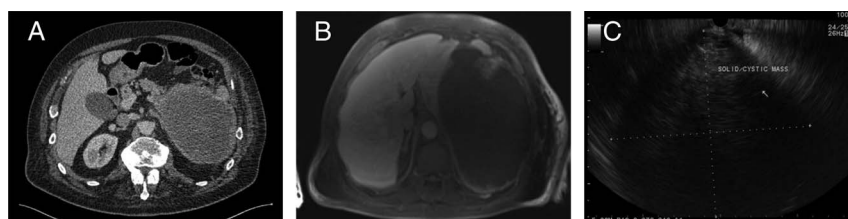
A 76-year-old man presented after a fall and a trauma series. Computed tomography scan (A) demonstrated a large, complex cystic mass between the pancreatic tail and the spleen. Initially felt to be a hemorrhagic lesion following the recent trauma, the complexity of the lesion prompted MRI evaluation. The MRI (B) demonstrated the lesion to arise from an expanded pancreatic tail. The fluid contents of the lesion appeared of intermediate high signal on T1 suggestive of hemorrhagic or proteinaceous characteristic and with more solid components within the peripheries of the lesion. Percutaneous ultrasound-guided drainage of the lesion yielded serous fluid for analysis, although cytological results did not demonstrate any malignancy. The patient underwent an EUS (C), which demonstrated a large mixed cystic/solid lesion and FNB of the solid components confirmed the diagnosis of high-grade leiomyosarcoma.
